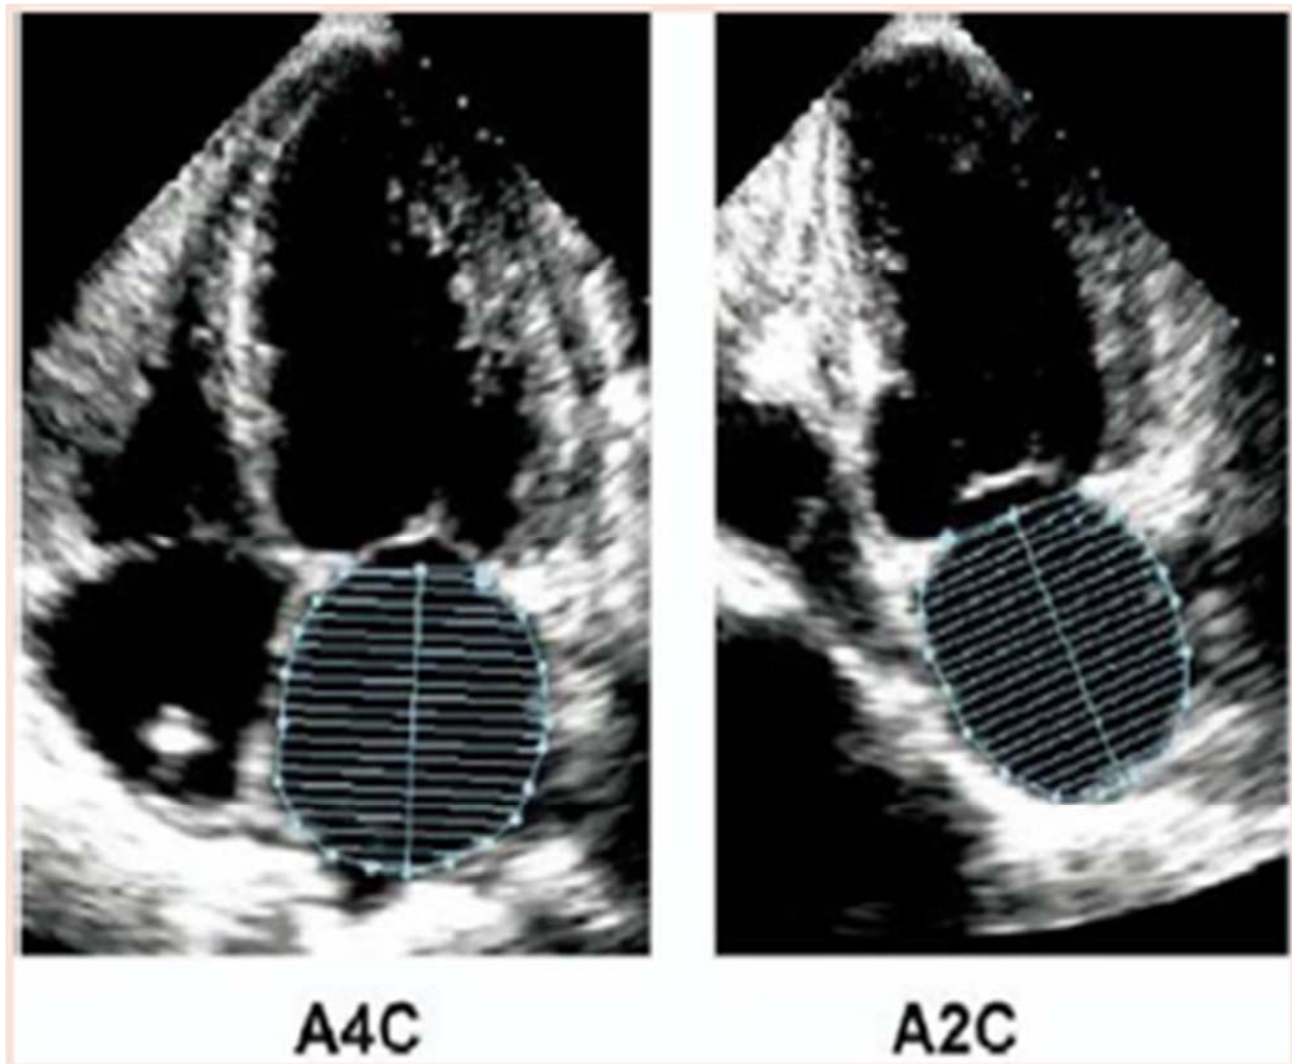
Still frame of apical 4 and 2 chamber views demonstrating bi-plane Simpson's method for quantification of LA volume. [Journal of the American Society of Echocardiography 2015 281-39.e14DOI: (10.1016/j.echo.2014.10.003) Copyright © 2015 American Society of Echocardiography]
